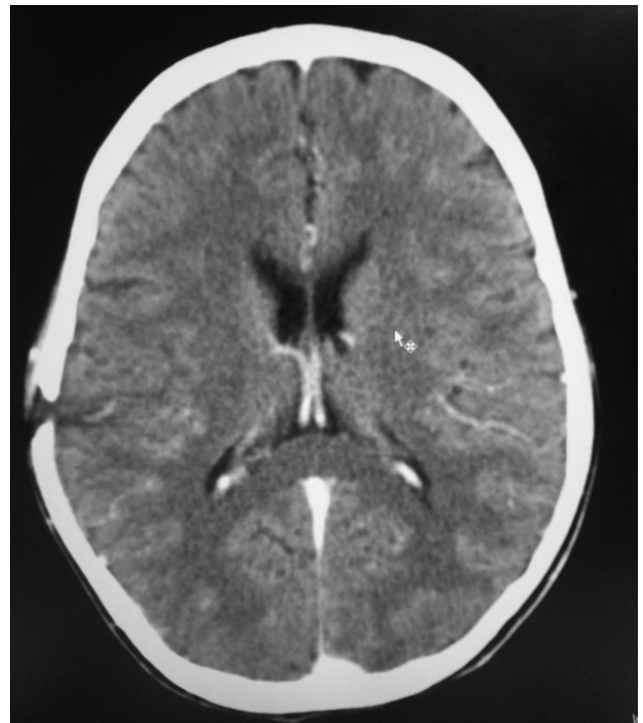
MRI scan shows the reduction of size of the abscess following treatment for three weeks.
